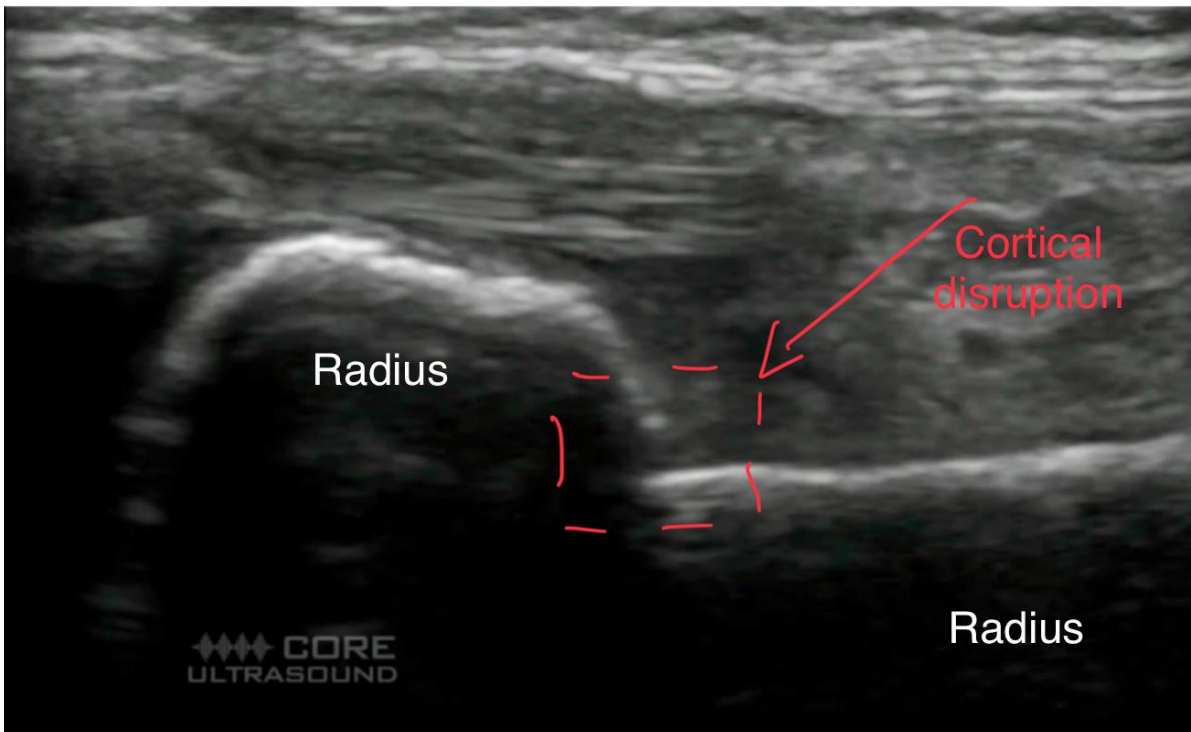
Sagittal image of distal radius showing disruption in cortex. Image from: <https://coreultrasound.com/fracture-and-hematoma-blocks/> (Image Modified by MB)
